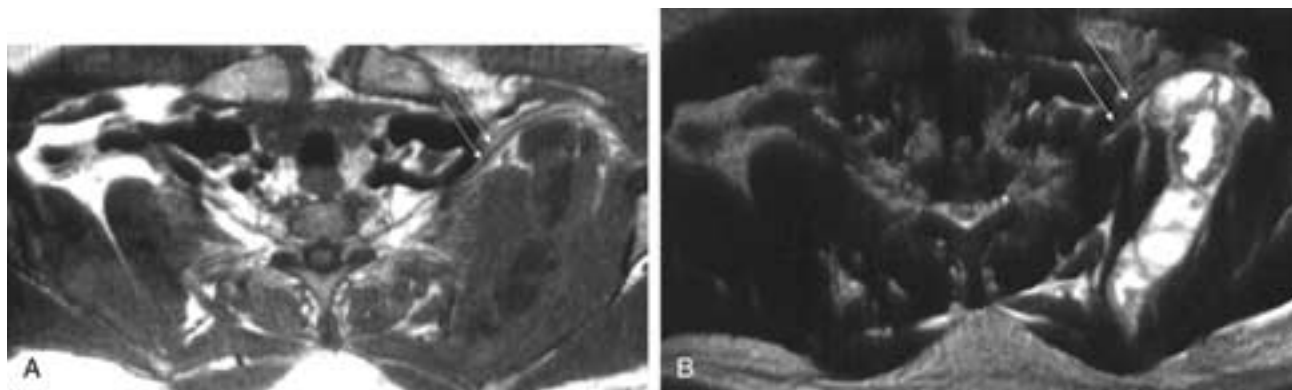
Metastatic melanoma—nodal disease. This patient complained of right arm discomfort. No physical evidence of brachial plexopathy was noted on physical examination. Axial T1-weighted (A) and T2-weighted (B) MR images show large, bulky, centrally cystic masses stretching the brachial plexus (arrows). No extracapsular disease was noted.
